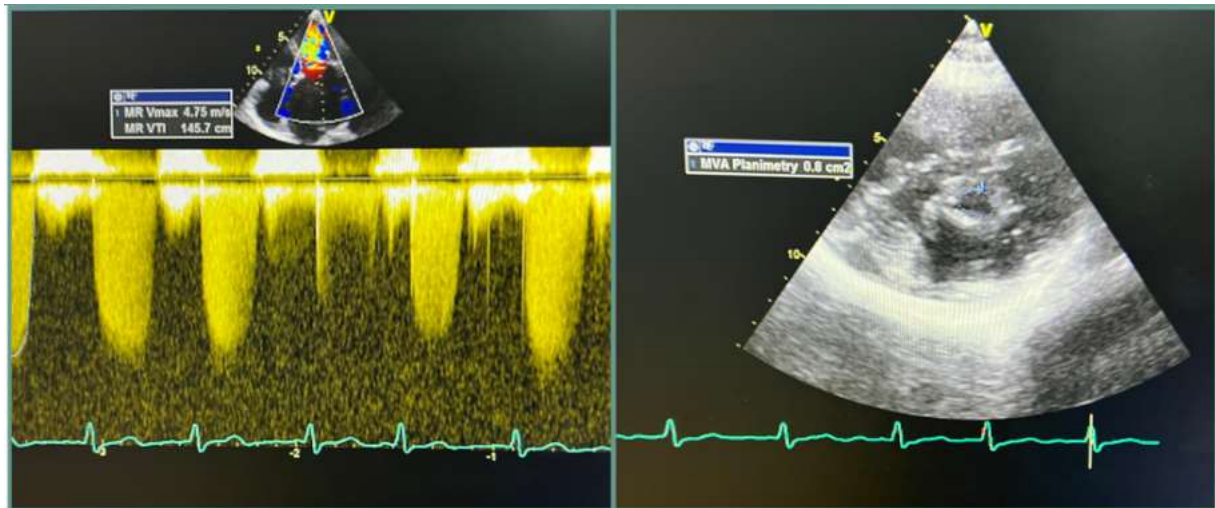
Echocardiography showed rheumatic heart disease, high probability of PHT ((TR VMax 4.01 m/s; PVACCT 80 ms. est PASP 74.46 mmH) severe mitral stenosis, severe mitral regurgitation, mild aortic stenosis, mild aortic regurgitation, mild tricuspid regurgitation, mild pulmonary regurgitation and normal left ventricle function (EF by MOD A4C 67 %; by MOD A2C 67%, Biplane 68 %).
